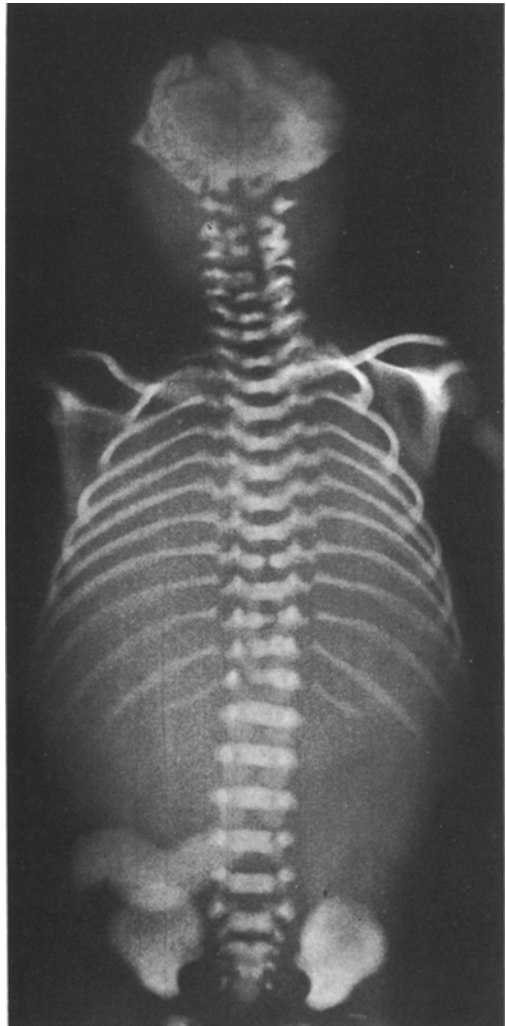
X-ray picture of fetal skull and spine
